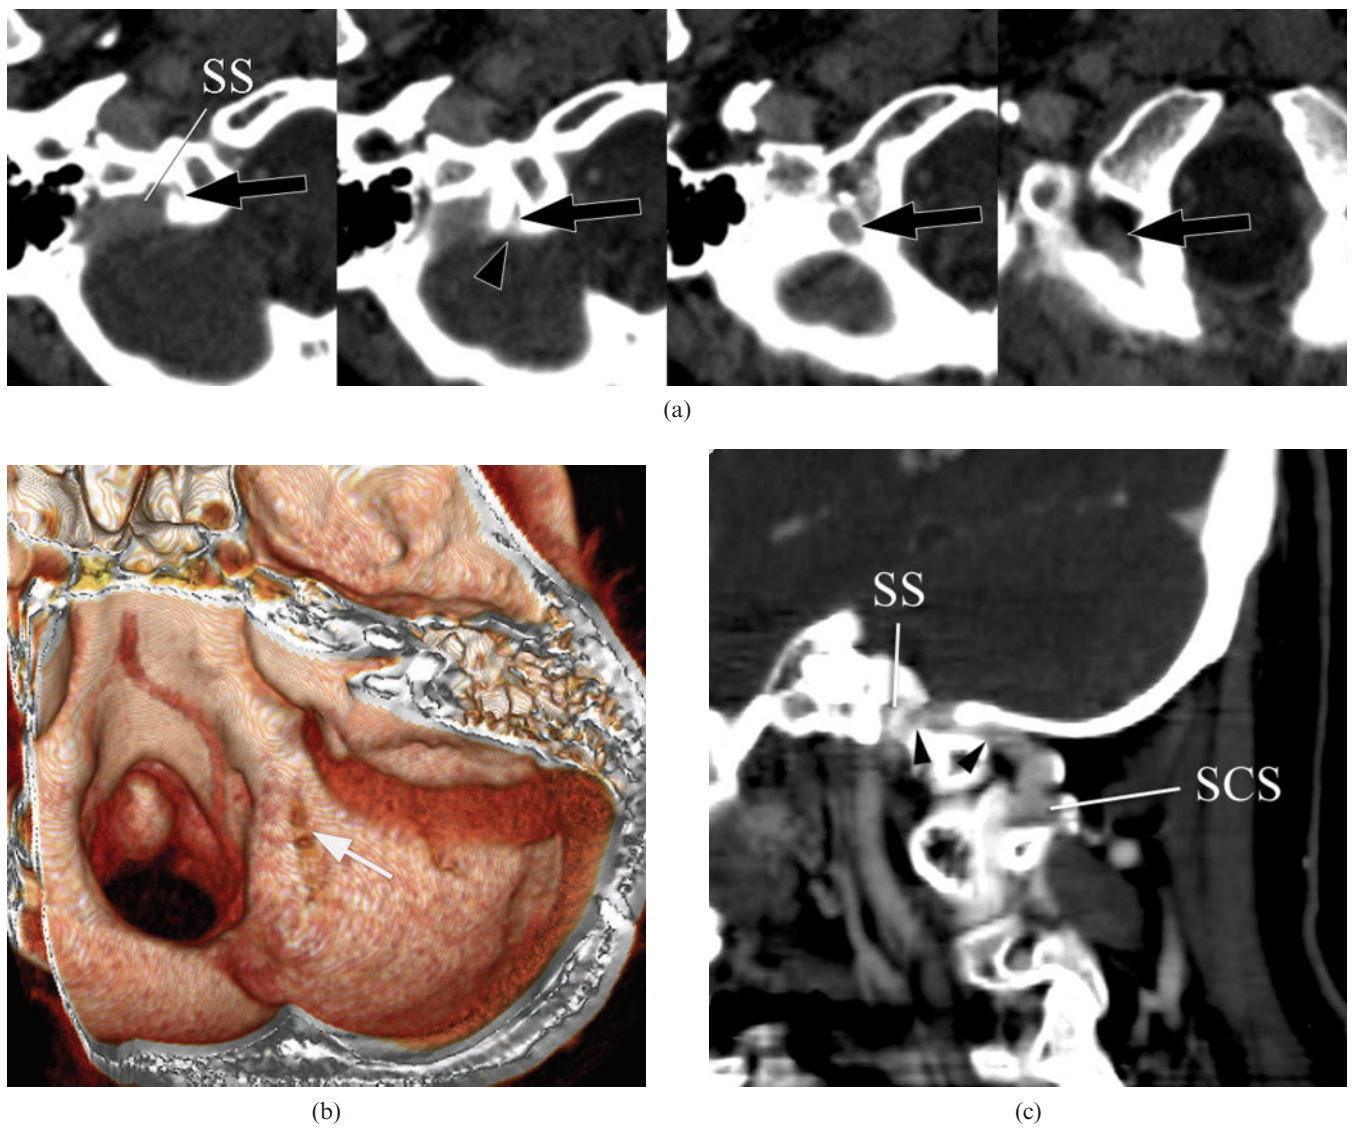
A 43-year-old male with malignant glioma. (a) Axial CT images show the posterior condylar vein (PCV) running through the posterior condylar canal (arrows). The posterior condylar canal is exposed at the intracranial surface of the occipital bone (arrowhead). (b) This three-dimensional reconstructed image shows the posterior condylar canal exposed at the intracranial surface of the occipital bone (arrow). (c) The PCV is demonstrated continuously on this oblique sagittal multiplanar reconstruction image (arrowheads). SCS, suboccipital cavernous sinus; SS, sigmoid sinus.
